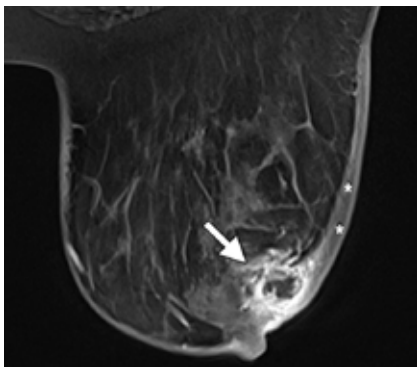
Breast MRI showing a breast abscess with rim enhancement (arrow) and adjacent skin thickening (*)
